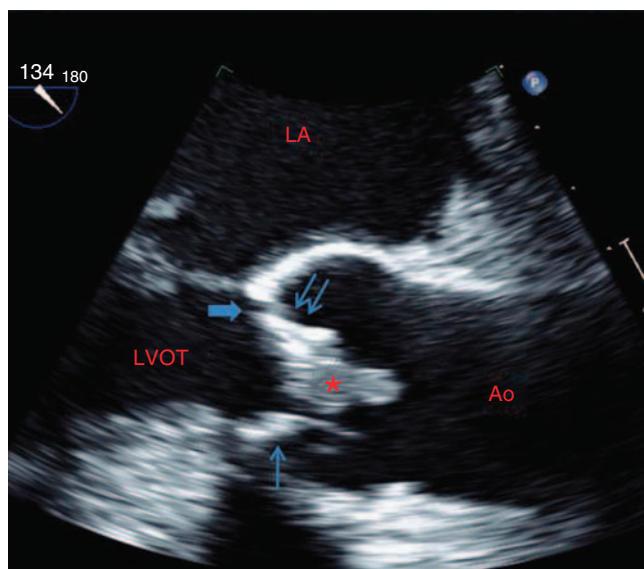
Two-dimensional transesophageal echocardiogram image of the aortic valve in mid-systole with opening of the non-coronary cusp (↑↑) and the right coronary cusp (↑). A large vegetation (*) is attached to the aortic (Ao) side of the non-coronary cusp, with an associated perforation (thick arrow) of the cusp. LA, left atrial; LVOT, left ventricular outflow tract.
